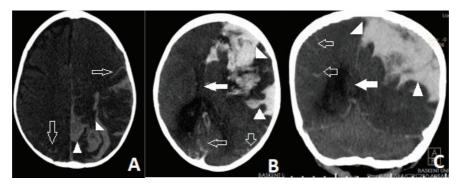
Brain Computed Tomography of Intracranial Hemorrhage
